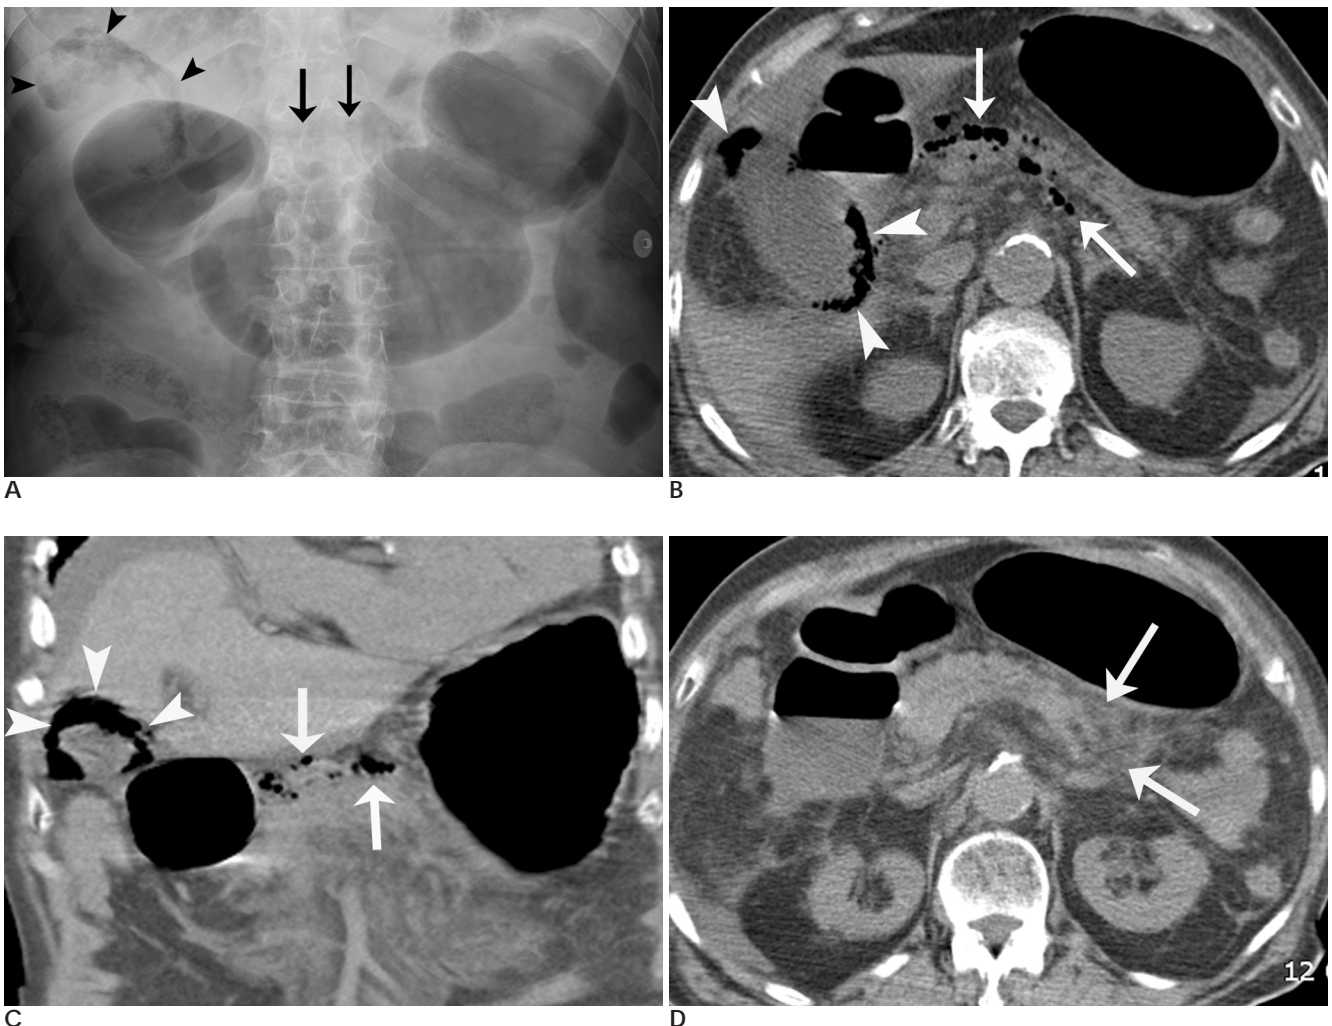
A 97-year-old man with concurrent emphysematous cholecystitis and emphysematous pancreatitis. A. A supine abdominal radiograph performed upon hospital admission revealed gas collection around the gallbladder shadow (arrowheads) and mottled gas bubbles in the upper middle abdomen (arrows). The stomach and duodenum are distended with gas. B, C and D. An axial CT scan (Fig. B) without intravenous contrast media and a coronal reformatted image (Fig. C) show gas collections (arrowheads) in the wall of the distended gallbladder and mottled gas bubbles (arrows) in the head and body of the pancreas. An axial CT scan (Fig. D) shows peripancreatic inflammatory changes (arrows).
